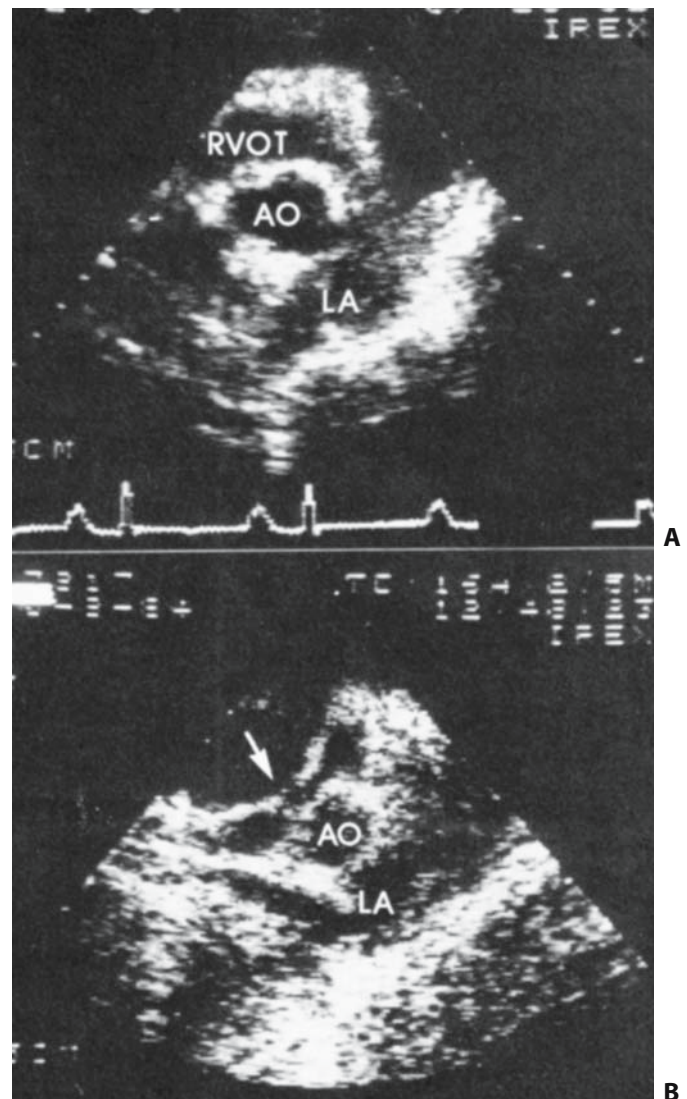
Subcostal view echocardiogram. (A) Normal appearance of the right ventricle. (B) Right ventricular early diastolic collapse.
